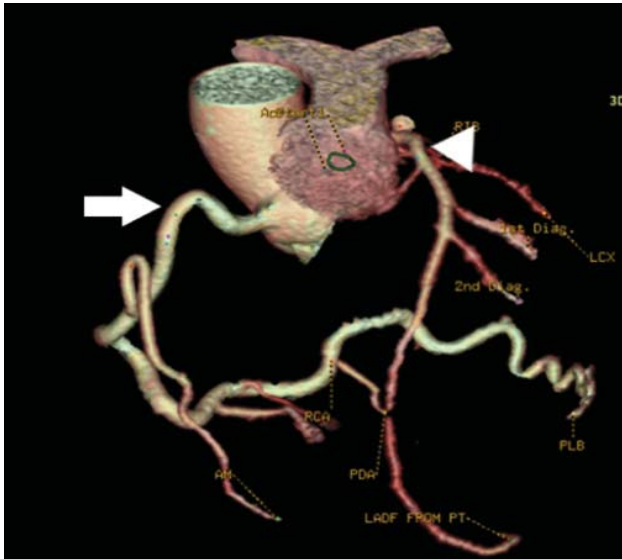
CT angiography volume rendered reformatted image showing vessels only. Relatively small sized Left coronary artery is emerging from pulmonary artery trunk (Arrow head) with its branches namely LAD and LCX. Right coronary artery is dilated and tortuous arising from right coronary sinus (Arrow) with its branches namely AM and PDA.
